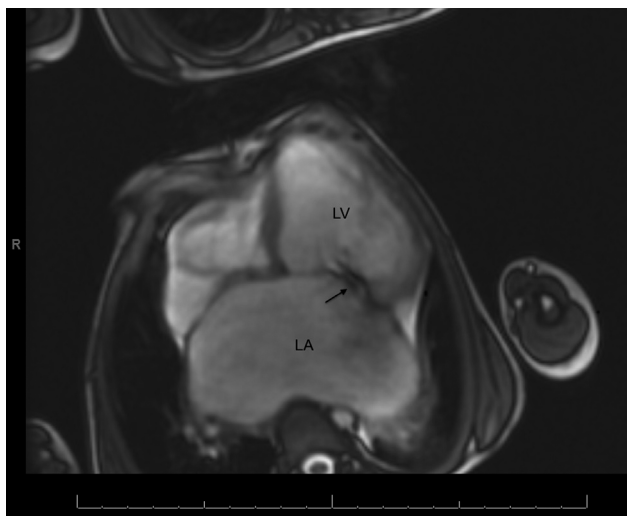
Magnetic resonance image (4-chamber view; obtained with steady-state free-precession MR sequence). Note thickened mitral valve leaflets (arrow), massively enlarged left atrium (LA) and enlarged left ventricle (LV) resulting from mitral regurgitation.
